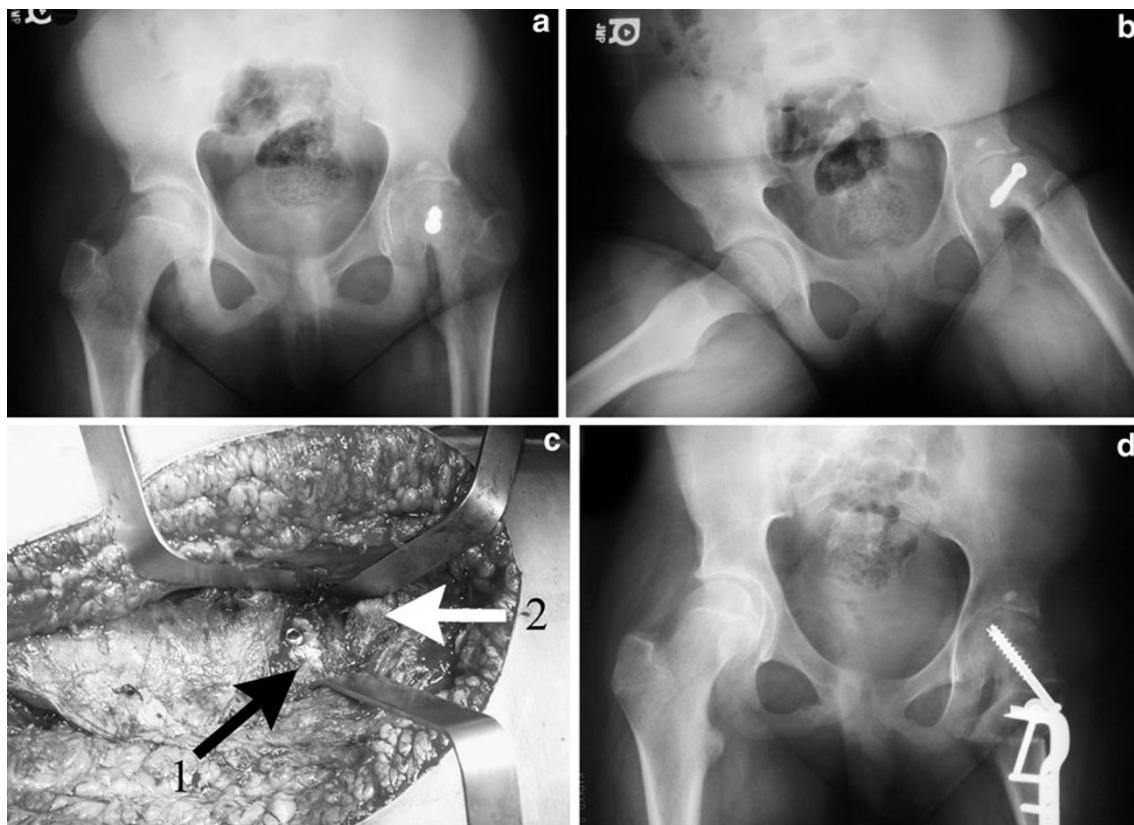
a, b Radiographs of a teenager with a severe slip who was treated with in situ fixation but who had significant signs of impingement at follow-up. The screw head appears to be above and medial to the intertrochanteric line. c Intraoperative photograph
